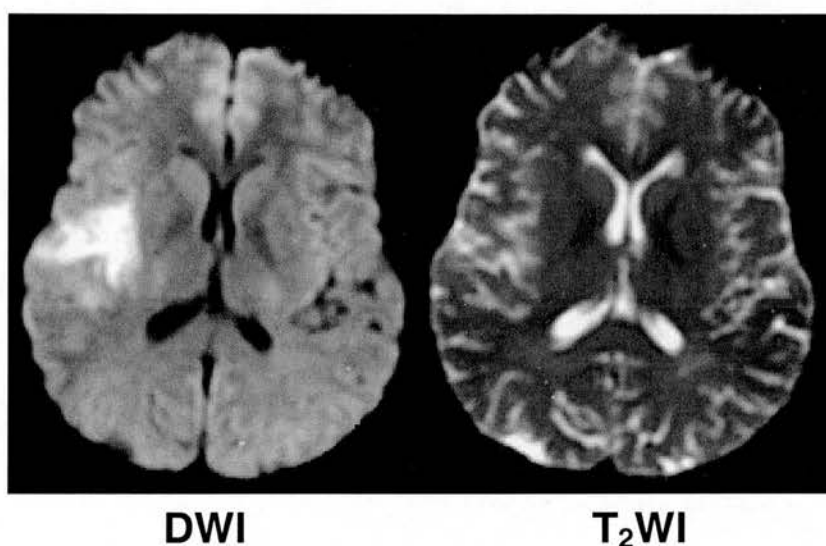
DWI and T₂WI from a patient with a right hemisphere ischaemic lesion at 6 hours after stroke onset. Note the hyperintense DWI lesion, and minimal (if any) visible T₂WI lesion.
